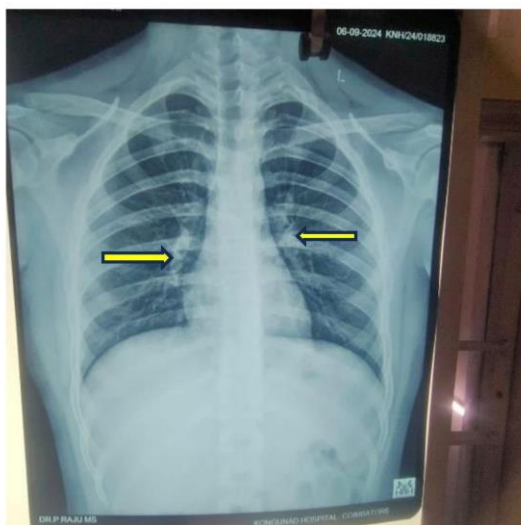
Chest X-ray of a 6-year-old male child showing bilateral increased broncho-vascular markings.
